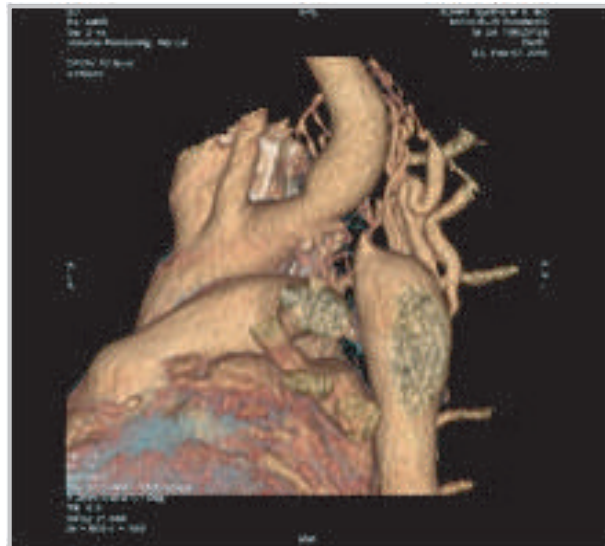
CT aortography showing coarctation of aorta, post stenotic aortic dilatation, multiple dilated collaterals, and dilated subclavian artery and PDA.
